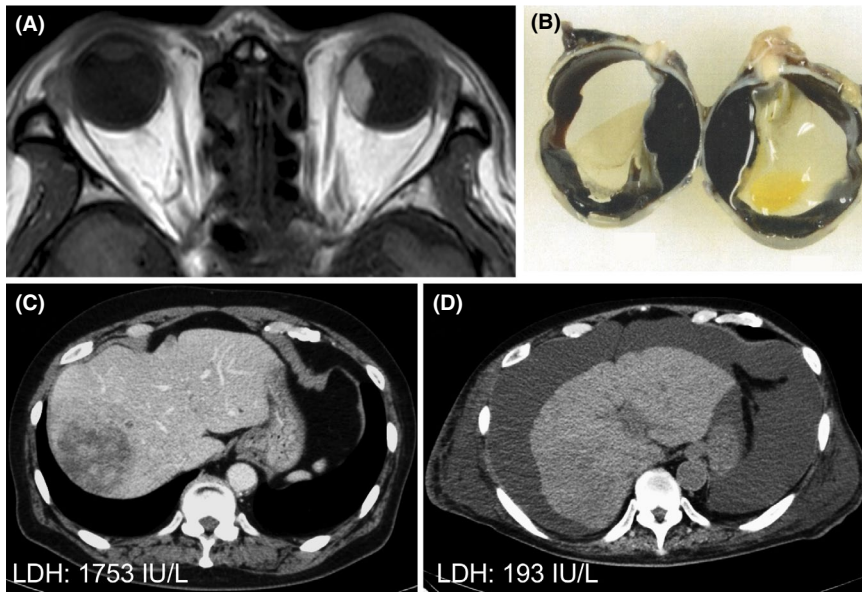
A, Magnetic resonance imaging on T1W1 shows a $16 \times 12 \times 17$ -mm tumor attached to the choroid of the left eyeball. B, Gross pathological finding of the extirpated left eyeball. C, Before treatment with dual checkpoint blockade, computed tomography (CT) reveals multiple low-density areas in the liver, with the largest measuring 52×63 mm and located in the S6. D, Two months after the onset of tumor lysis syndrome (TLS), CT shows a blurred tumor shadow. Note the large amount of ascites surrounding a shrunken liver and decreased serum lactic acid dehydrogenase level
